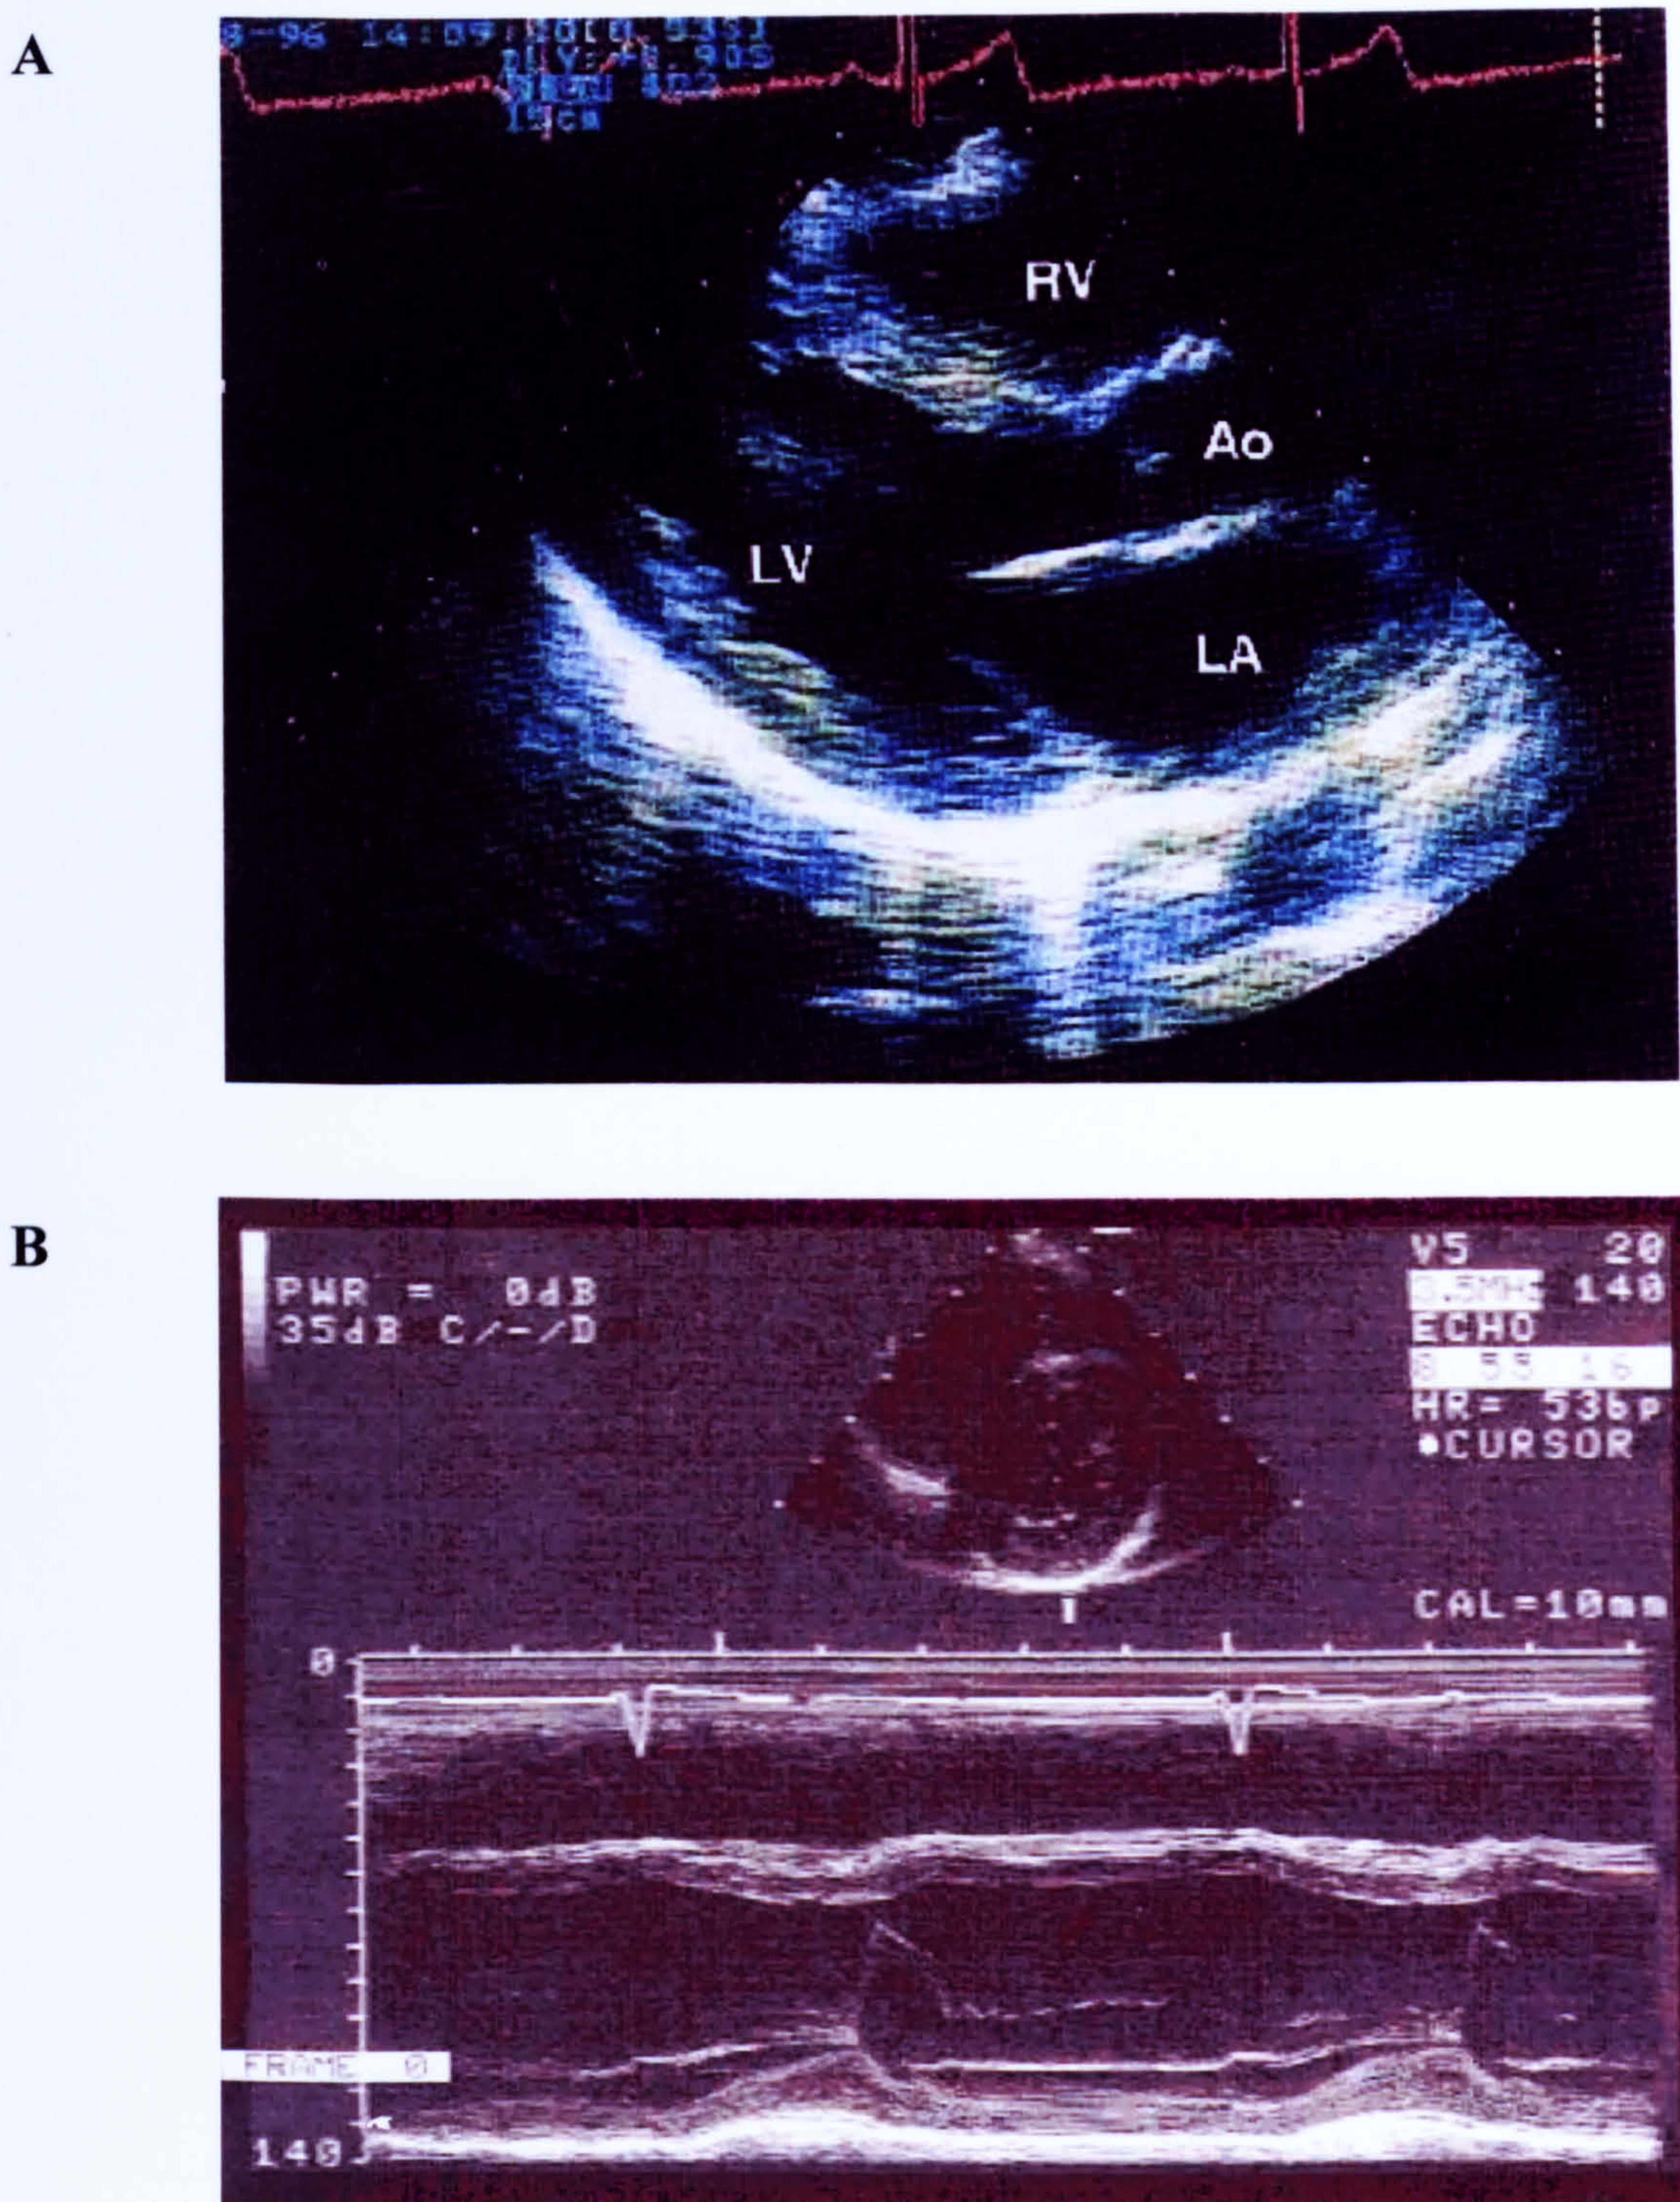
Cardiac dimensions using echocardiography
